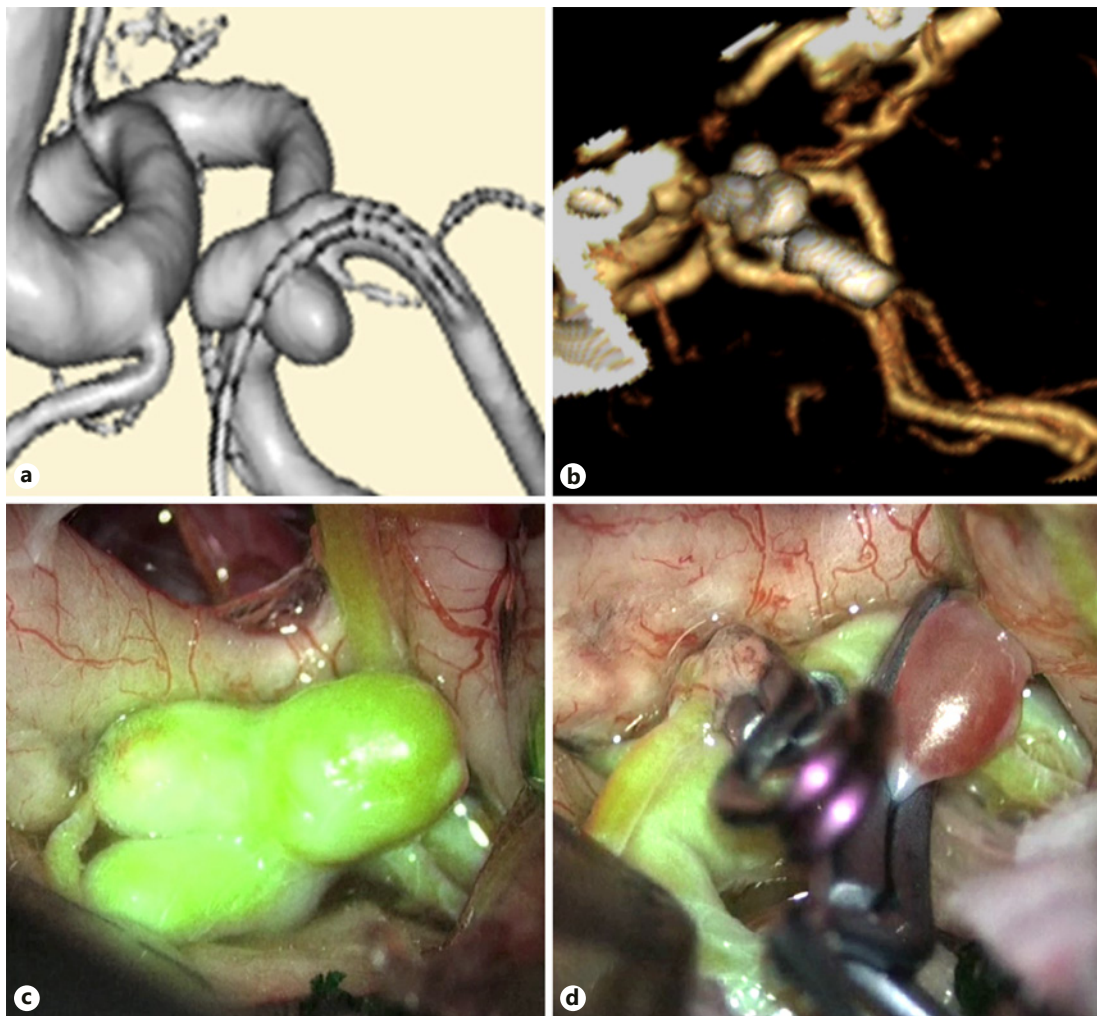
a Preoperative magnetic resonance angiography showing an anterior communicating artery aneurysm. b Postoperative three-dimensional computed tomography angiography showing no aneurysm remnant after clipping. c Dual-image videoangiography showing the anatomical relationship between the anterior cerebral artery, median artery of the corpus callosum, and recurrent artery of Heubner with the surrounding brain structures. d Dual-image videoangiography noticeably revealed the preservation of blood flow in the anterior cerebral artery and obliteration of the aneurysm with surrounding brain structures and clip positions.
